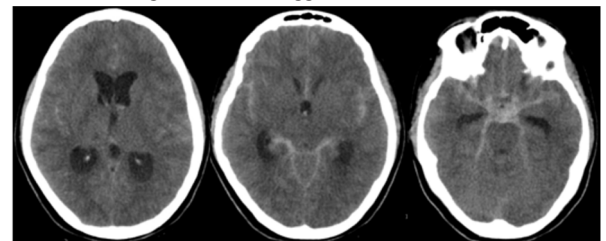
Computed tomography of the patient with acute subarachnoid haemorrhage along bilateral sylvian fissure, frontal and temporal cortical sulci, Acute SAH in suprasellar, quadrigeminal, prepontine, perimesencephalic, and cisterna magna and visualised extent of cervical spinal canal with acute intraventricular hemorrhage in frontal horn of lateral ventricle, third and fourth ventricles causing mild obstructive hydrocephalus.
